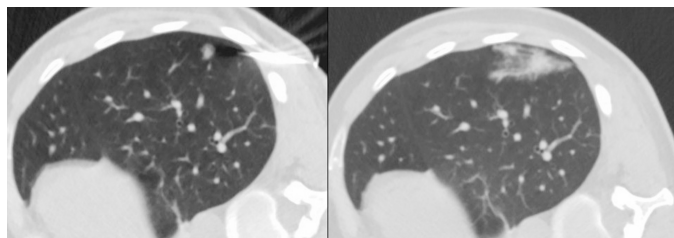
Biopsy of a small and semi-solid lesion. (a) CT image during needle insertion. (b) In control image after needle removal, needle tract alveolar haemorrhage is seen.
